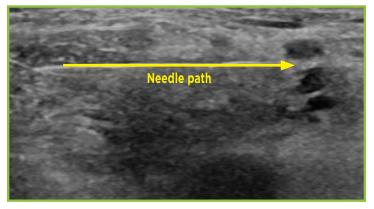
Interscalene brachial plexus nerve block ultrasound.
